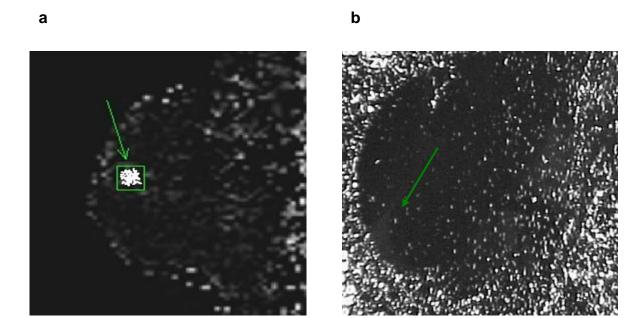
The relative breast blood volume maps reconstructed from the T_2 *-weighted perfusion MRI studies: (a) Compared to normal breast tissue areas, hyperintensity was observed in the region of a pathologically proven malignant tumor (arrow). (b) No enhancement was seen in a pathologically proven benign lesion (arrow), even though contrast enhancement was observed in the same lesion in the T_1 -weighted DCE MRI study.
